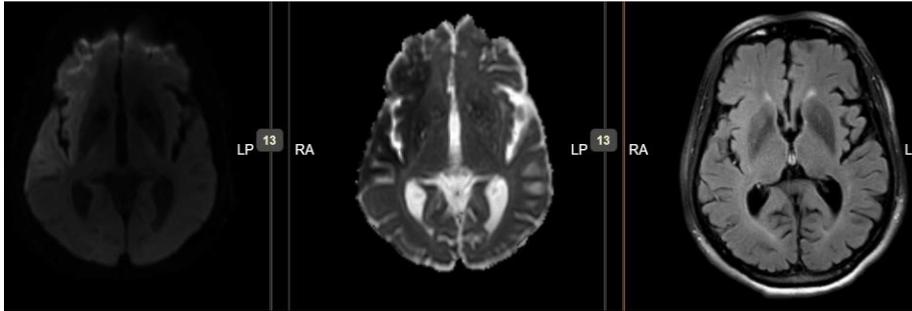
Large DWI core infarct involving right MCA territory. FLAIR signal is preserved in keeping with DWI-FLAIR mismatch
